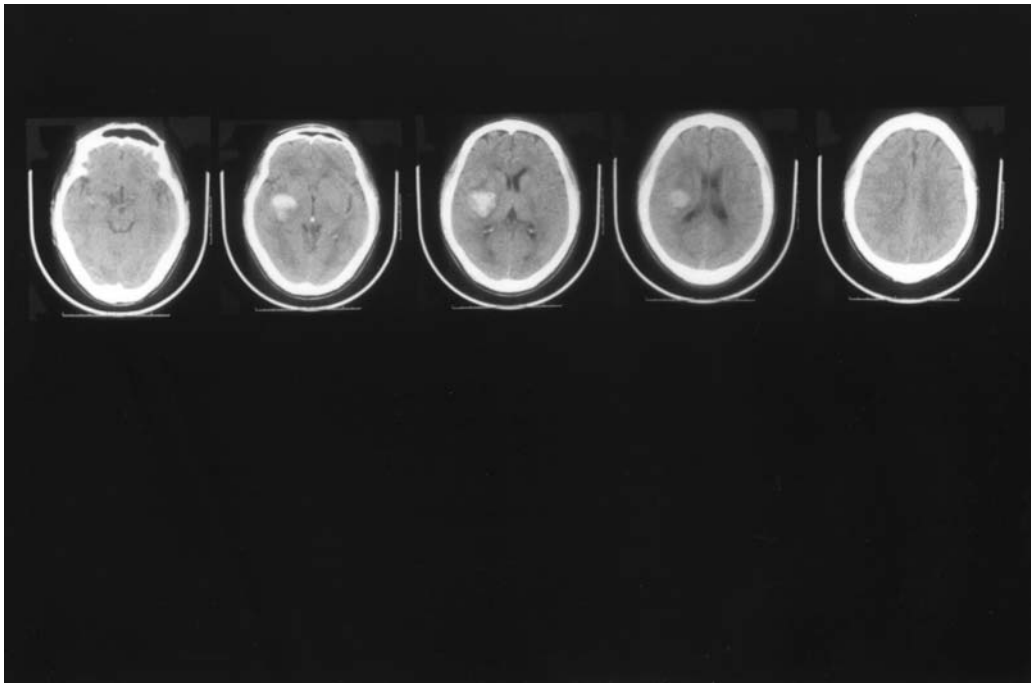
Computed tomographic scans of Pt. 7, with poor performance on the Copying Sentences on the initial examination, with right putaminal hemorrhage. Top: CT scan slices where hemorrhage was present at 1 day poststroke; the hemorrhage involved the putamen with posterior extension into the posterior limb, internal capsule; and superior extension into the corona radiata, lateral to the body of the lateral ventricle. Note, this case who had poor performance on Copying Sentences also had hemorrhage which extended into the superior white matter, lateral to the body of the lateral ventricle. No follow-up CT scan was available.
